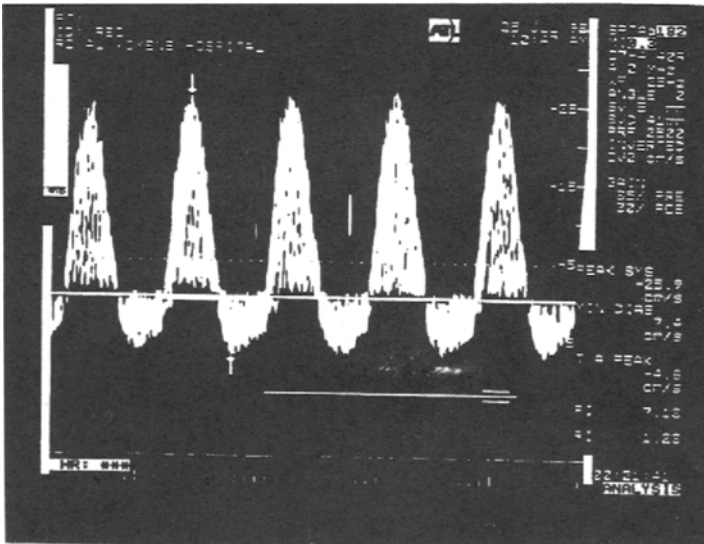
Doppler umbilical artery waveform pattern showing reverse diastolic flow.
